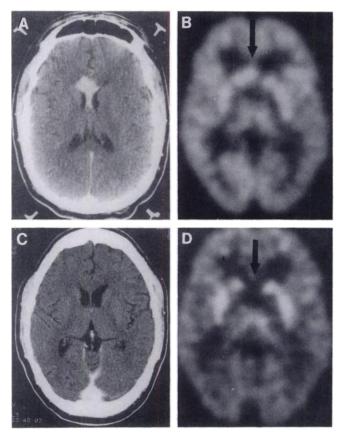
Contrast-enhanced CT (A,C) and FDG-PET (B,D) scans of a 25-yr-old male (Patient 1) with PCNS-L before (A,B) and approximately 3 wk after (C,D) treatment with dexamethasone. The arrows indicate the area of abnormal FDG accumulation that disappeared with steroid therapy.
